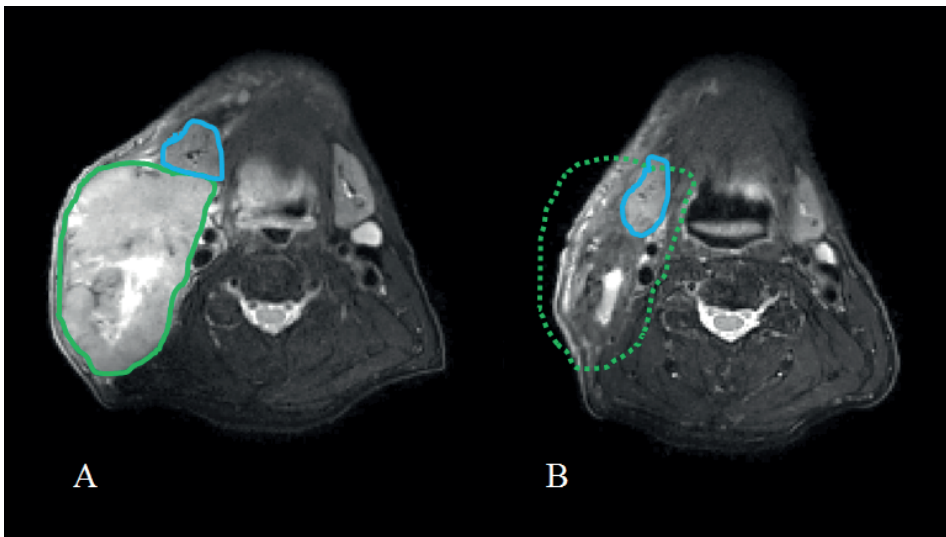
MR images of a patient with a T2N3M0 HPV positive oropharyngeal carcinoma. A: T2 weighted image acquired prior to the start of treatment. The large metastatic lymph node on the right side of the patient (green outline) pushes the submandibular salivary gland (blue outline) anteriorly. B: T2 weighted images after 4 weeks of chemoradiotherapy treatment. The lymph node has recessed as a reaction to the treatment and the salivary gland now shifted back to its original position. If the metastatic lymph node was planned to receive a high dose the salivary gland would have moved into that high dose area.
